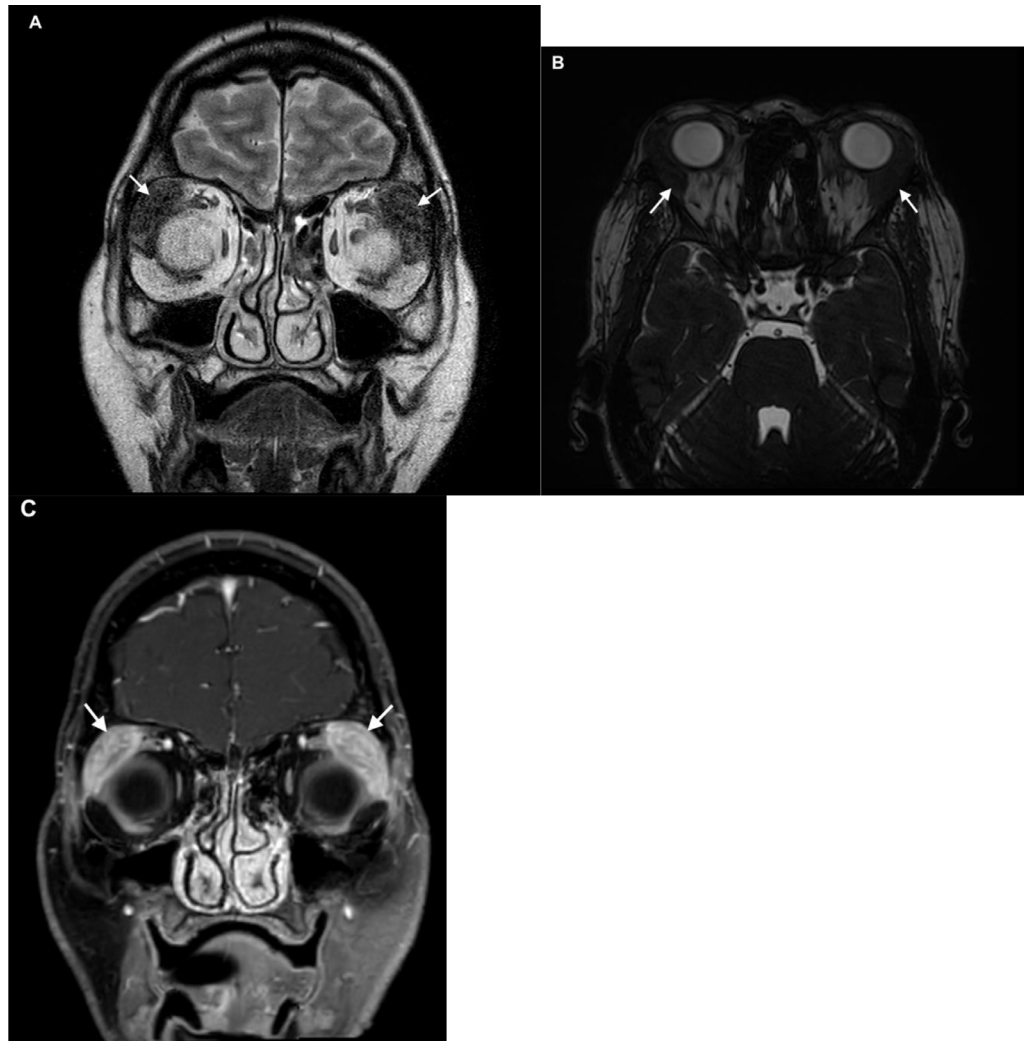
Orbital MRI with coronal T2-weighted sequence (A), axial T2 FIESTA (B), and coronal T1 FAT SAT after contrast injection (C), revealing bilateral and asymmetric enlargement of the lacrimal glands (yellow arrows). The glands exhibit an isosignal compared to the muscles, extending to the lateral rectus muscle and orbit without affecting them. There is subtle infiltration of extraconal fat, and intense enhancement is observed after contrast injection.
